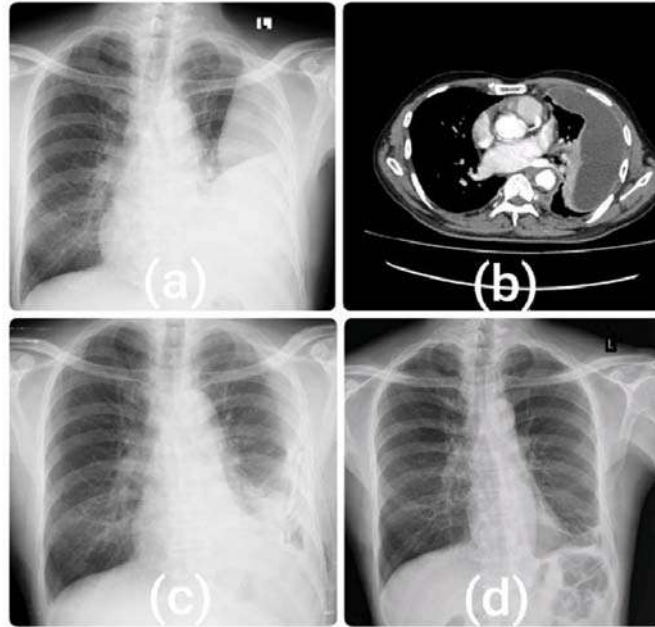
On admission chest X ray left side encysted effusion (a), enhance CT shows effusion with septations and lung consolidation (b), following ICD chest X ray (c), after IPFT on follow up 3 weeks chest X ray (d).
